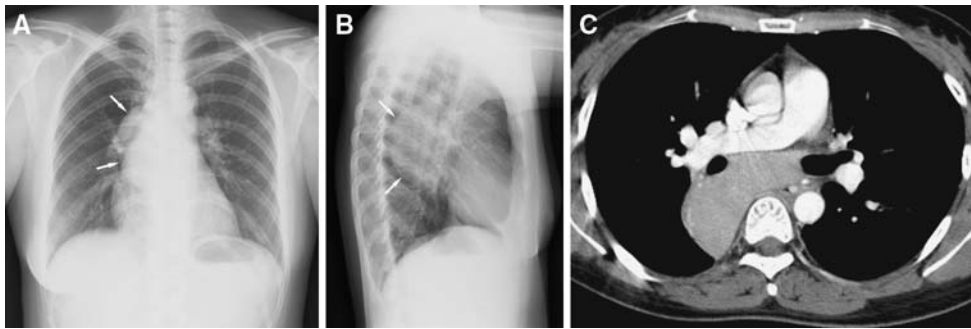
Chest X-ray and CT of a 31-year-old woman presenting a dry cough for 6 months. (A) Posteroanterior chest radiograph shows a large, homogeneous, and well-margined opacity (white arrows) that causes mediastinal widening, but does not blur the right border of the heart. (B) Lateral chest radiograph confirms its posterior location in the mediastinum. (C) Contrast-enhanced chest CT
